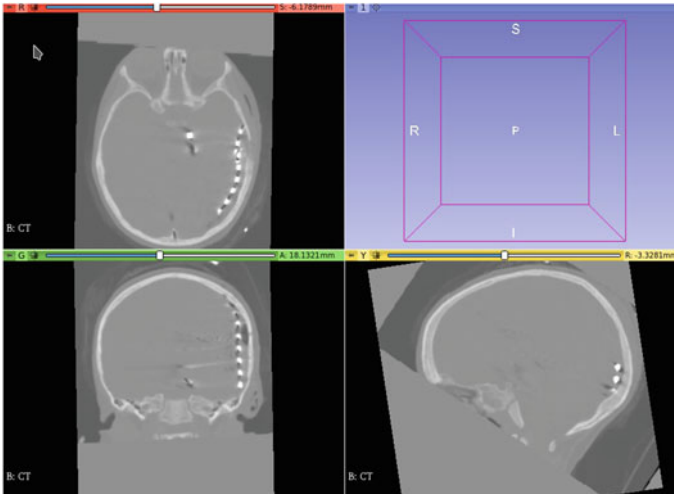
CT with intracranial electrodes implanted
